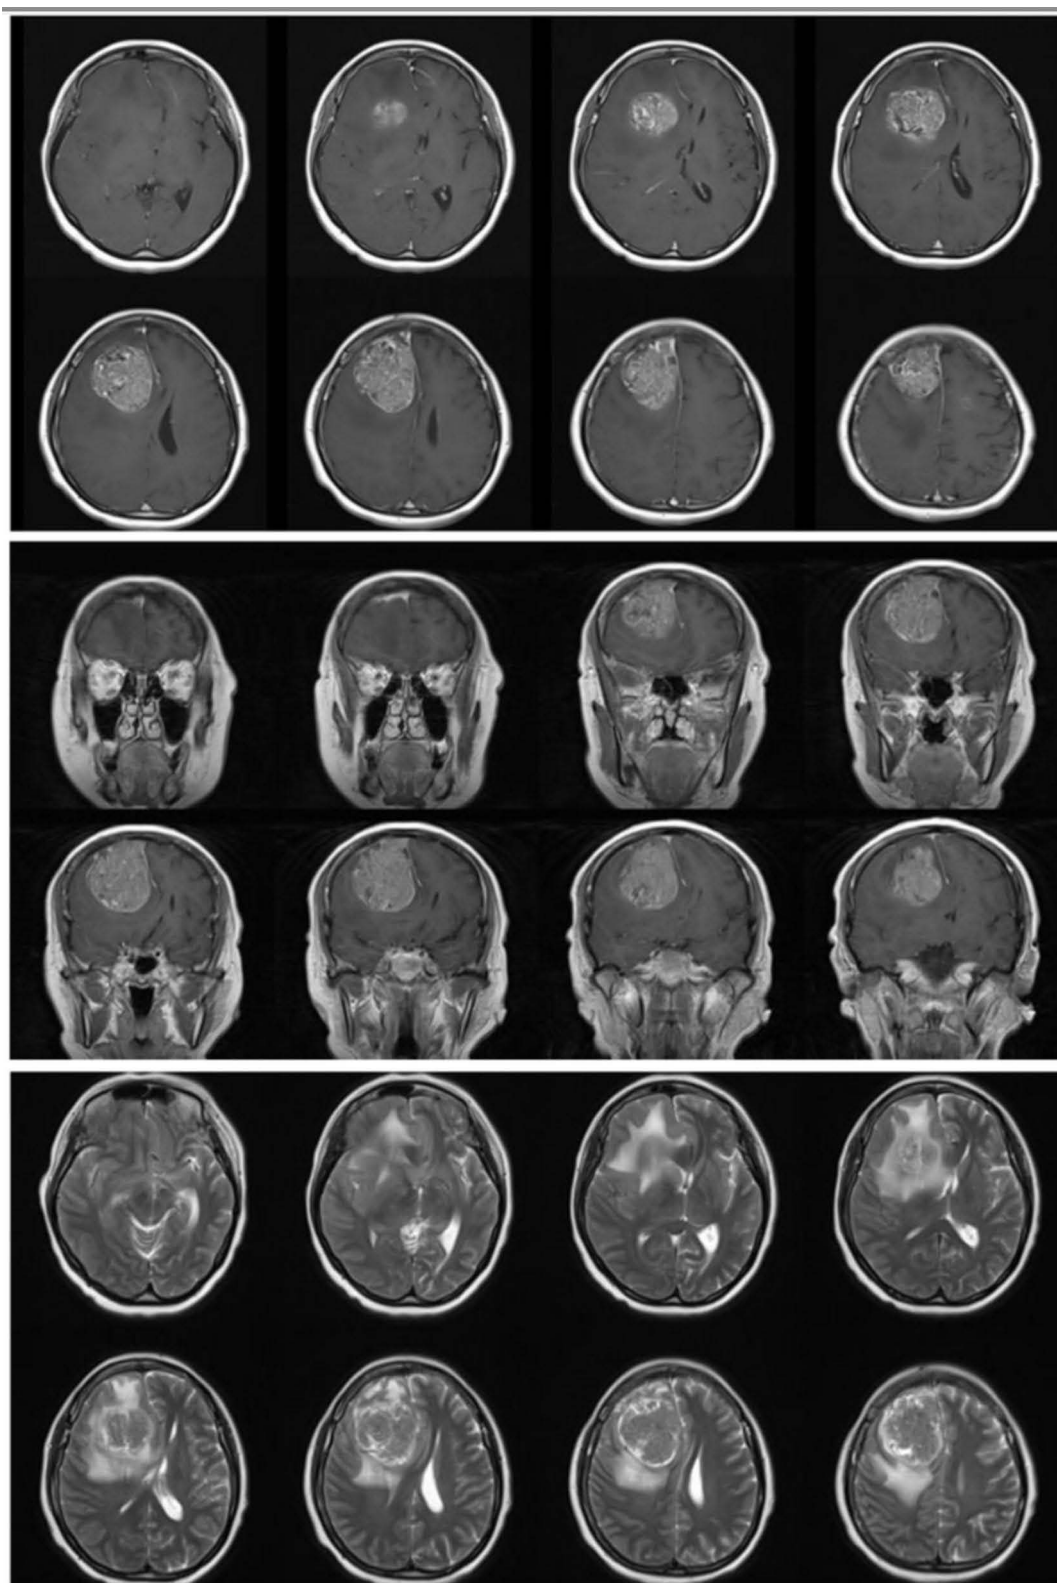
Axial MRI of the brain on T1-weighted imaging, multiple mixed-intensity lesions were observed in the right frontoparietal and left parietal regions, showing inhomogeneous enhancement following contrast administration. On T2-weighted imaging, the same multiple mixed-intensity lesions were noted in the right frontoparietal and left parietal regions, accompanied by positive perifocal edema.
